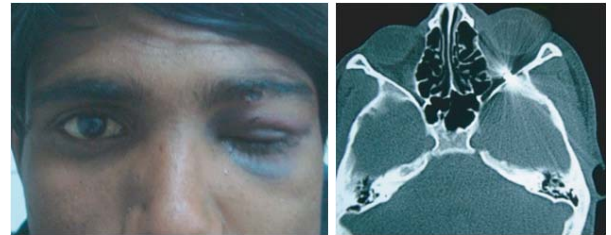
A 25-year-old male patient gave a history of gunshot injury to his left eye three days ago. The left upper eyelid shows a round entry point of a wound with periocular ecchymosis. The CT-Scan of the orbit (bone window) shows a round metallic foreign body with artifact in the posterior aspect of the left orbit. The diagnosis was the direct traumatic optic neuropathy of the left eye.
